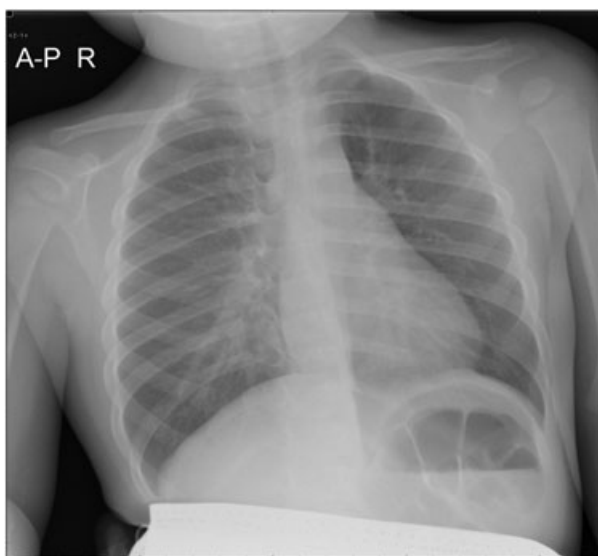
Radiograph of pneumonia and interstitial infiltrates in a 1.7-year old girl. Sole HBoV1-infection was serologically confirmed (16 respiratory viruses and four respiratory bacteria were searched by PCR from induced sputum samples, and *Mycoplasma* serology was performed). White blood cell count was $11.6 \times 10^9/L$, and serum C-reactive protein was 16 mg/L. Duration of respiratory symptoms was 6 days before hospitalization; during hospitalization, symptoms included fever, cough, and dyspnoea. The radiograph was kindly provided by Dr. Elina Lahti from the Department of Pediatrics, Turku University Hospital, Turku, Finland
